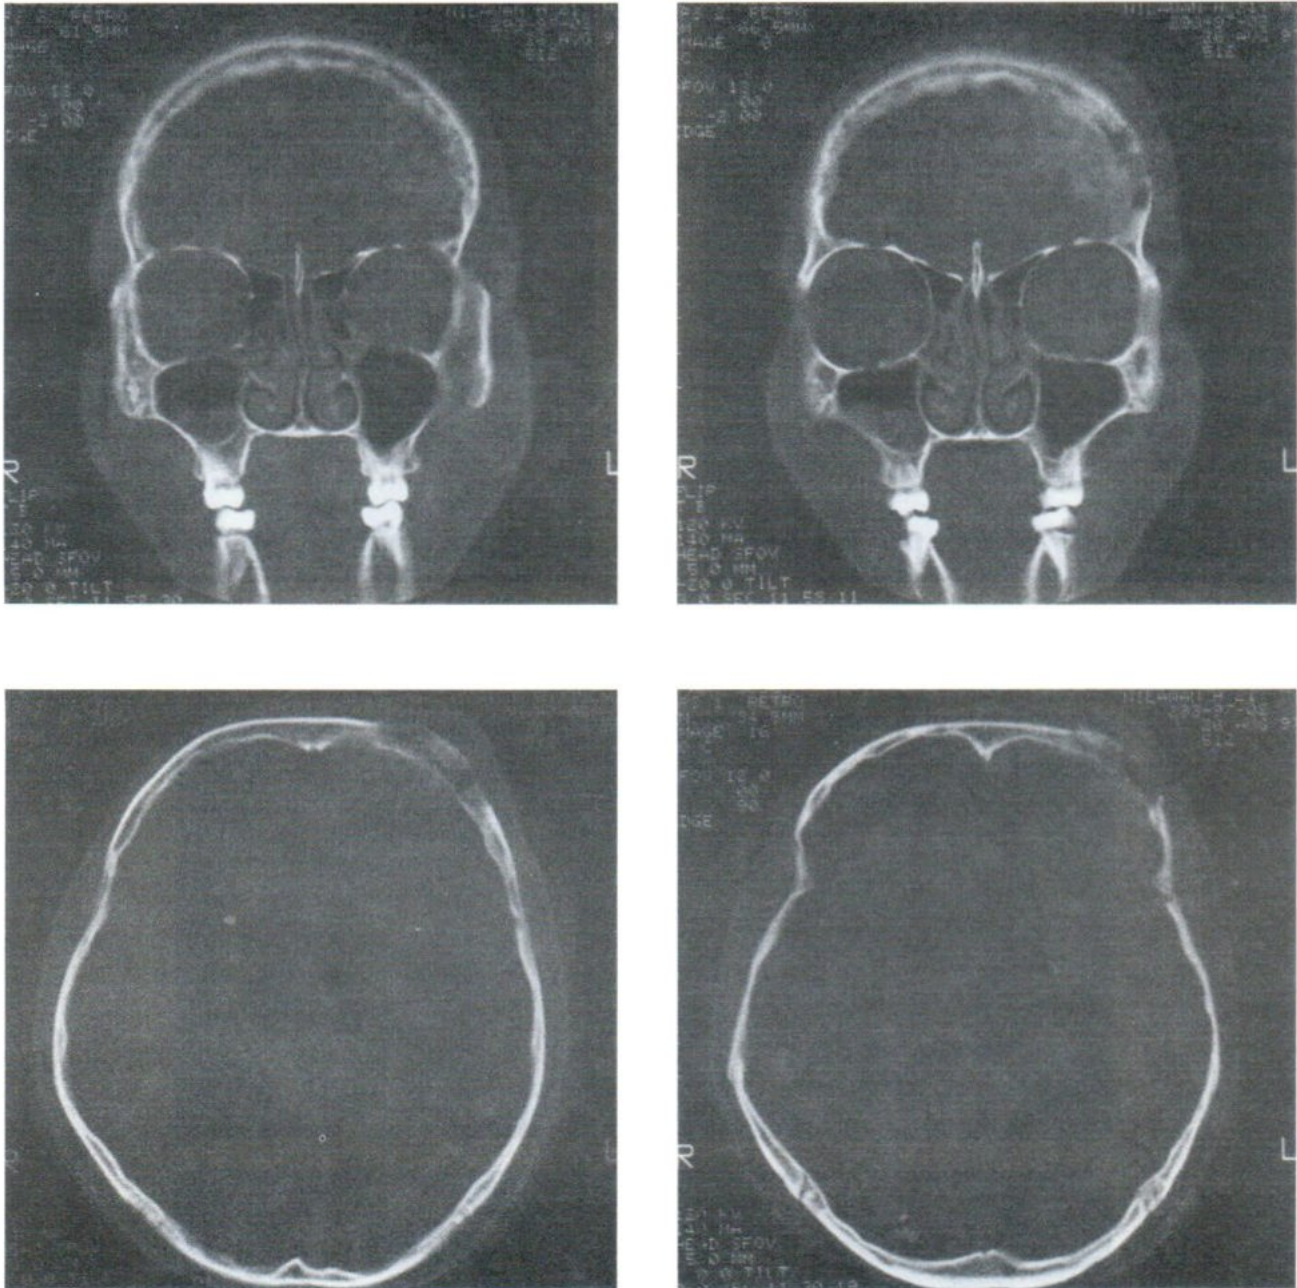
Case 1. Bone window of the CT scan revealed that the destruction of the all table-layers of the frontal bone was obvious. The destruction was composed of osteolytic and permeative areas.
